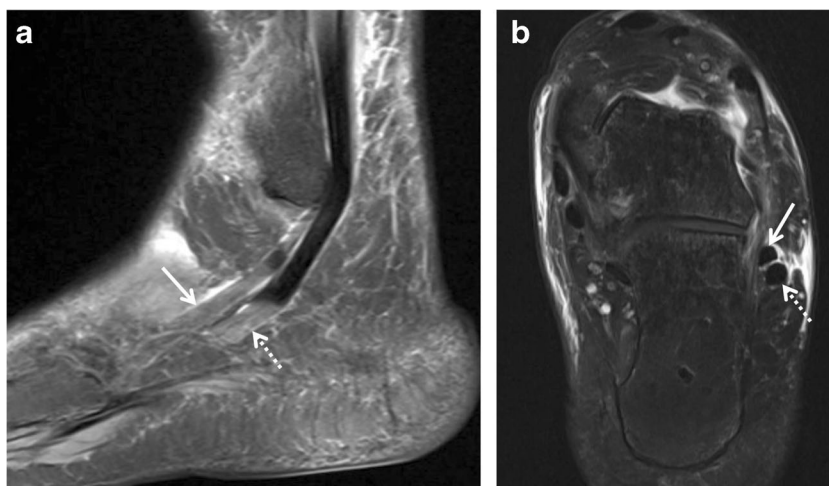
Pseudotear of the peroneal tendons due to magic angle artifact. The sagittal PD-weighted fat-saturated MR image (a) obtained on a 3-Tesla MR system shows focal increased signal within the peroneus longus (*dashed arrow*) and brevis (*arrow*) tendons at the lateral calcaneus that is
